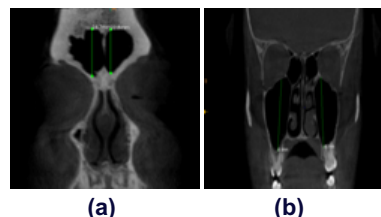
Figure (a) and (b):CBCT images showing measurement of the height of frontal (a) and maxillary sinus (b) from coronal section.
